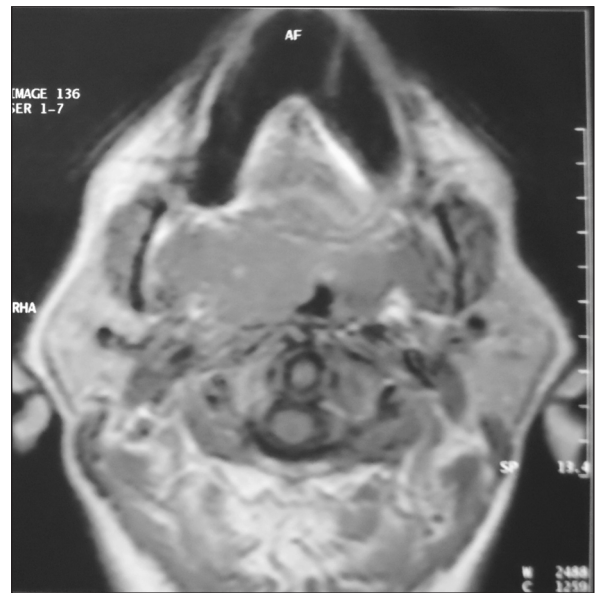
Axial plane MR imaging of the patient showing right tonsillar mass of 3x3cm.
